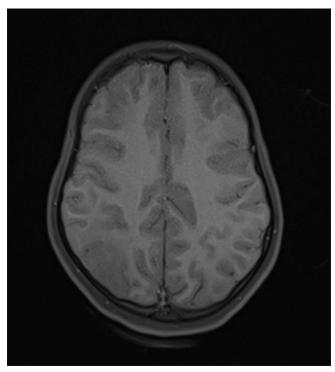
Magnetic resonance imaging (MRI) brain of the patient showing acute infarct involving parieto-occipital lobe on the right side.
